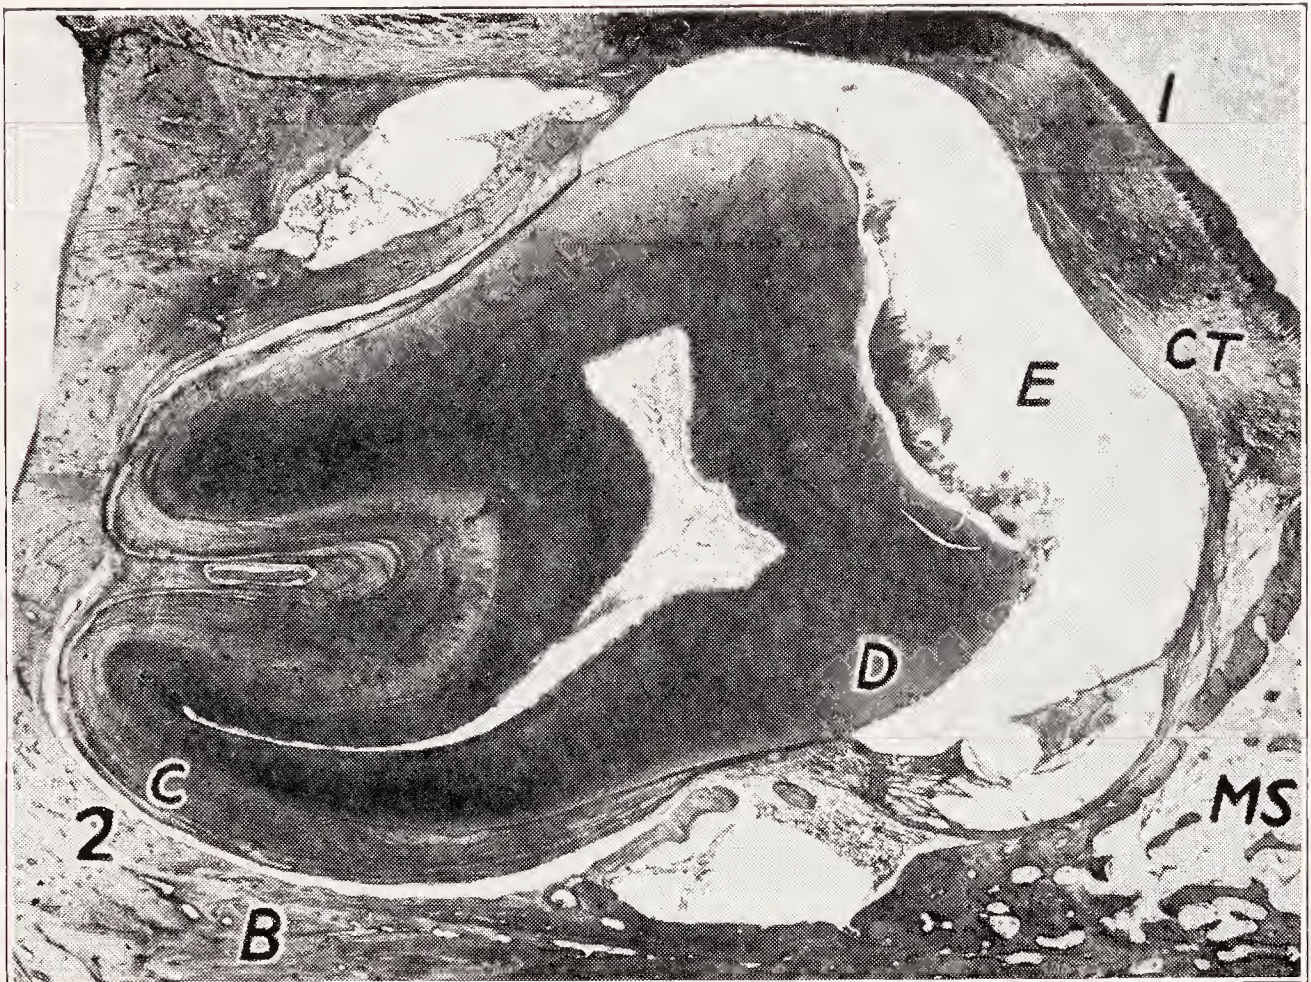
Mesio-distal section through the completely embedded lower left third molar of a man, thirty-eight years old. *CT*, oral mucosa and connective tissue covering crown; *E*, enamel space; *D*, dentin; *C*, thick layers of cementum; *B*, bone; *MS*, marrow spaces. The area marked 1 is shown in Figure 373 in higher magnification. (Logan, Jour. Am. Dent. Assn.)
